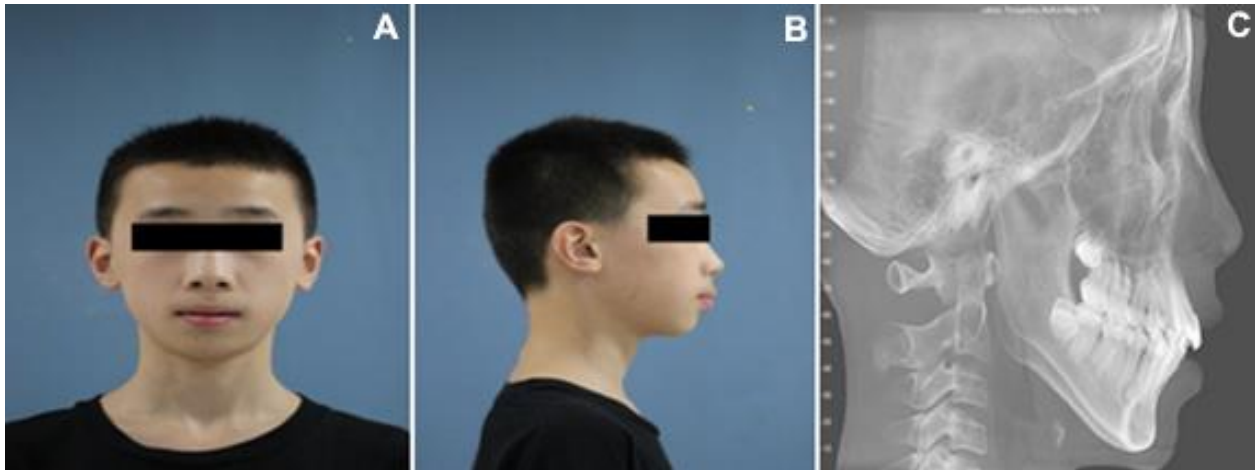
Pretreatment extra oral photographs and lateral cephalometric radiographs of a patient with hyperdivergent skeletal pattern. (A) Frontal view of the patient with increased lower anterior facial height (LAFH), (B) profile view of the patient with obtuse mandibular plane (MPA) angle, and (C) increased the height of mandibular ramus. Authors authenticate that the consent form of the patient was acquired appropriately. The patient has provided his approval in the consent form for his photographs and clinical and radiographic records to be expressed in the manuscript.
